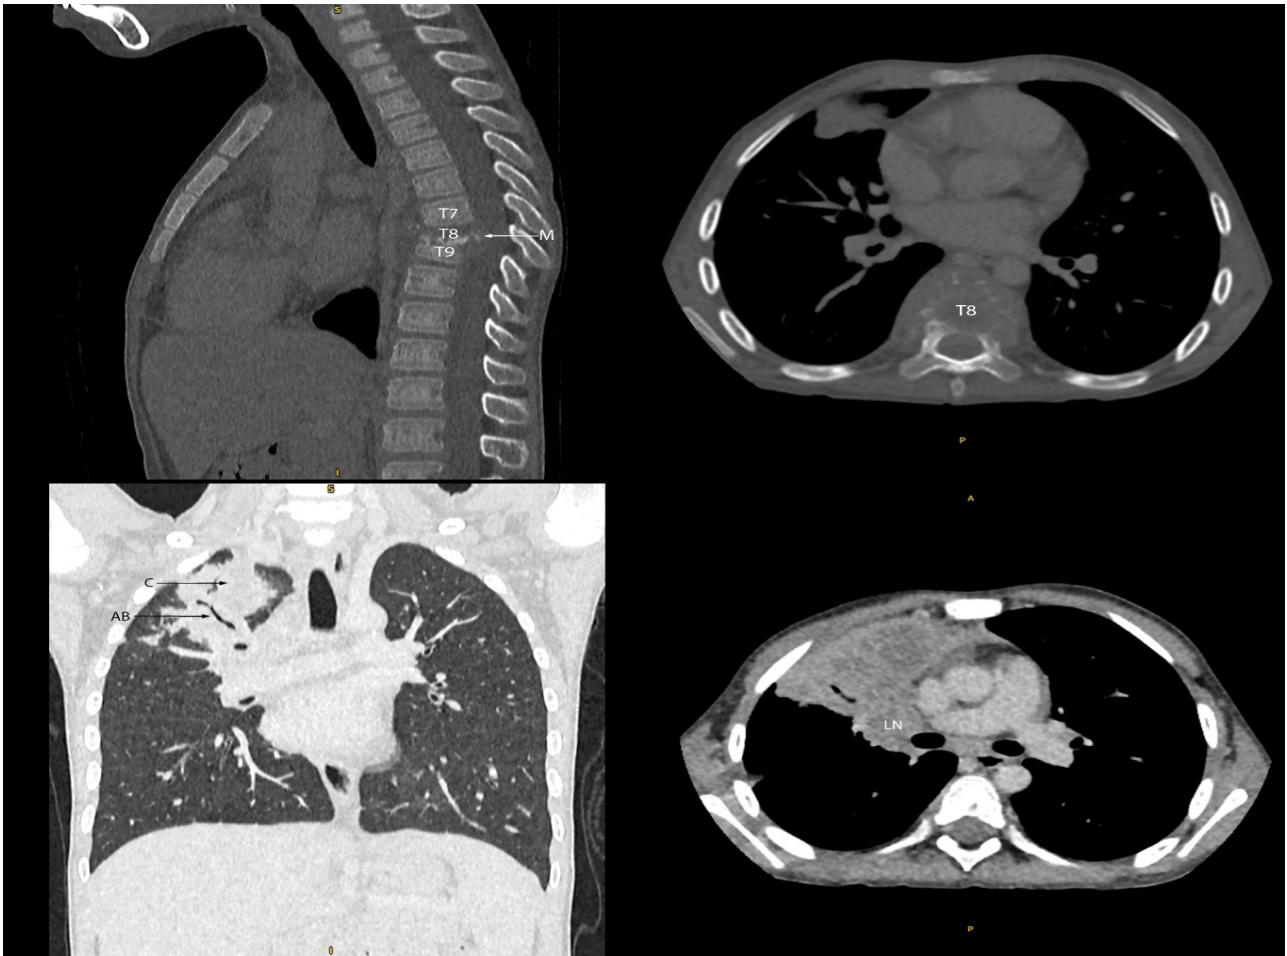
CT Thorax shows dense consolidation in the anterior segment of the right upper lung with air bronchograms (AB) with enlarged lymph nodes (LN). There is also gibbus formation and destruction of the T8 and T9 vertebral bodies, associated with a paraspinal soft tissue mass (M).
